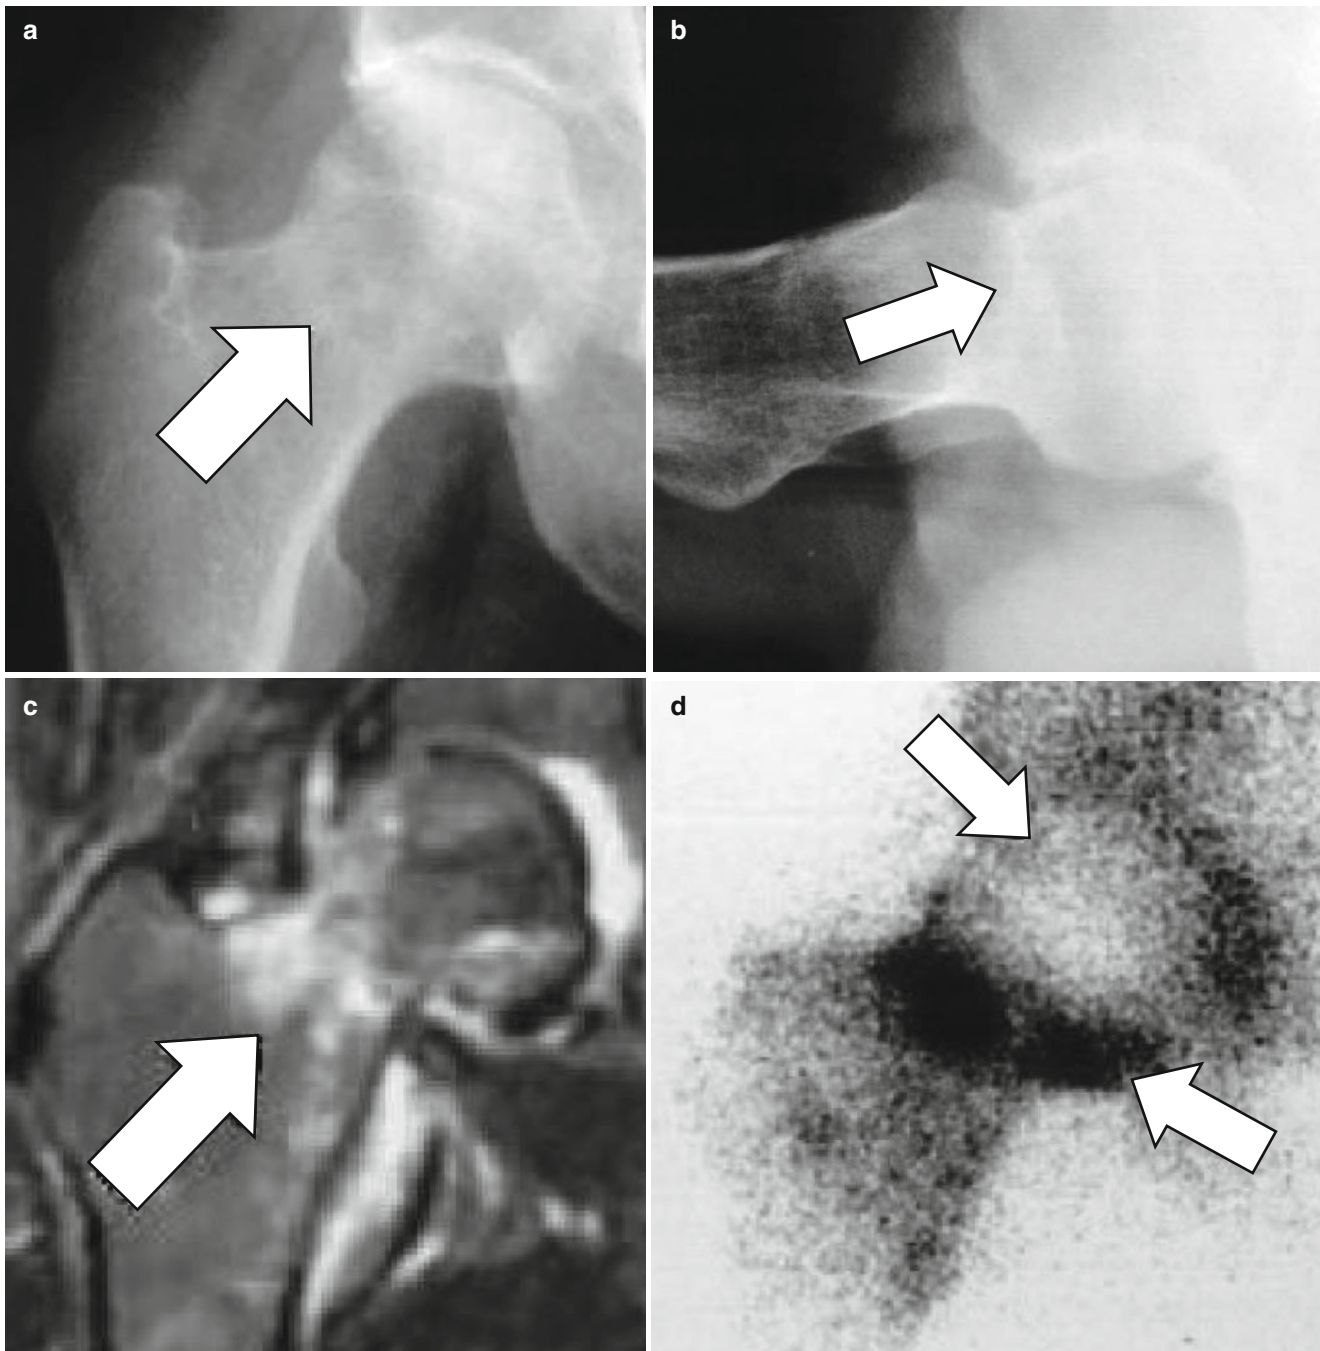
Plain radiographs of a 45-year-old man with right femoral osteonecrosis show linear sclerosis (*arrow*) in the right femoral neck (a, b). These look like a femoral neck fracture pattern (High signal
